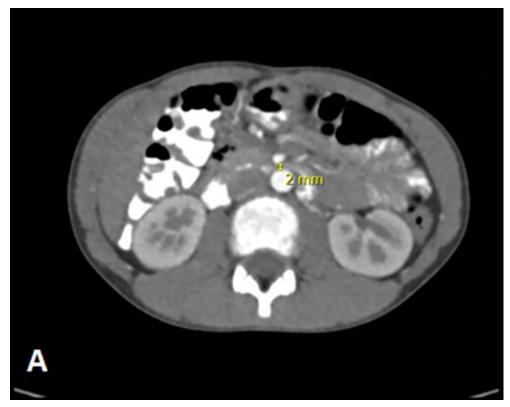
Axial CT of the abdomen with intravenous and oral contrast shows reduced aorto-mesenteric distance of 2 mm (normal > 8mm)
